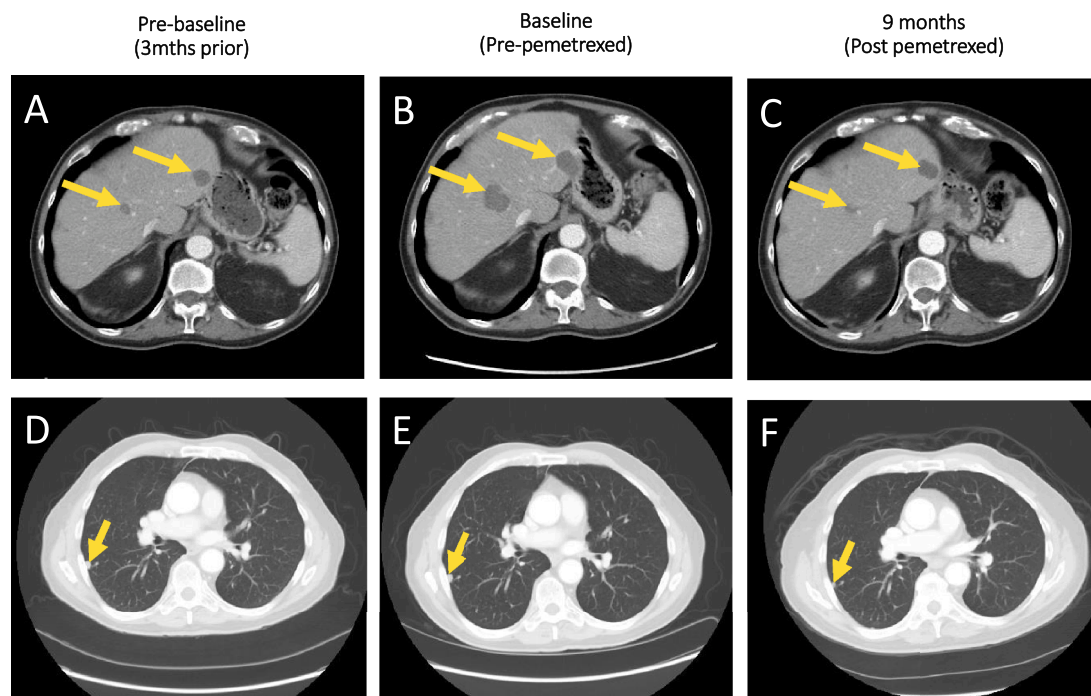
A–C: Abdominal CT with contrast showing changes in the size of tumors in the liver before and after treatment with pemetrexed. D–F: Chest CT with contrast showing changes in the size of lung tumors before and after treatment with pemetrexed.
